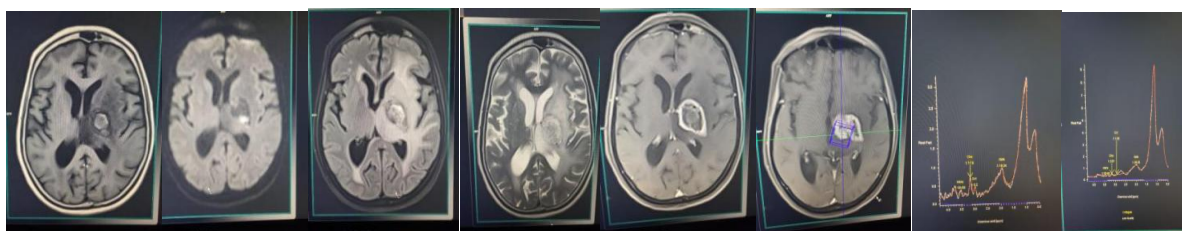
Primary tumour T1, T2 FLAIR Mixed intensity lesion with hypointense rim, moderate adjacent edema, on post contrast thick nodular peripheral enhancement with central necrosis in the left capsuloganglionic region s/o Primary tumour.
